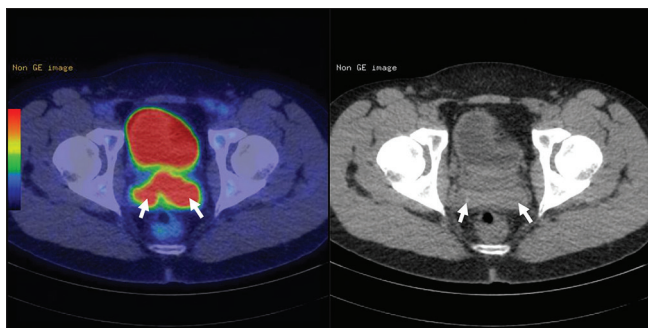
Axial fused fluorodeoxyglucose (FDG) positron emission tomography/computed tomography (CT) (left) and unenhanced CT (right) images demonstrating marked FDG avidity within enlarged seminal vesicles (arrows) extending into the adjacent prostate. No further sites of FDG avid disease were demonstrated
